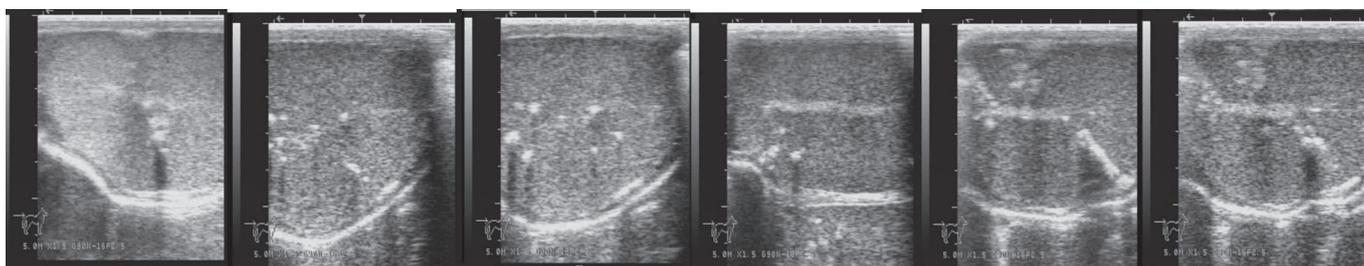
Ultrasonogram of ram testes showing various degrees of fibrosis with calcification
